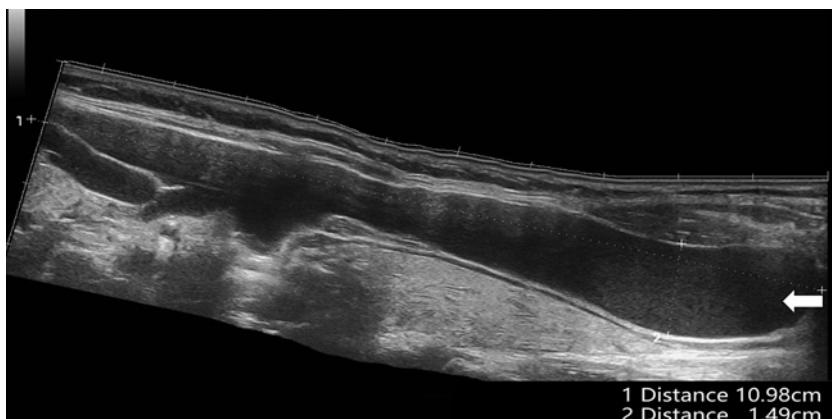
Ultrasonography. An echo-free fluid formation in the left anterior cervical region with a craniocaudal extent of 10.98 cm and anteroposterior dimension of 1.49 cm (the arrow points).
